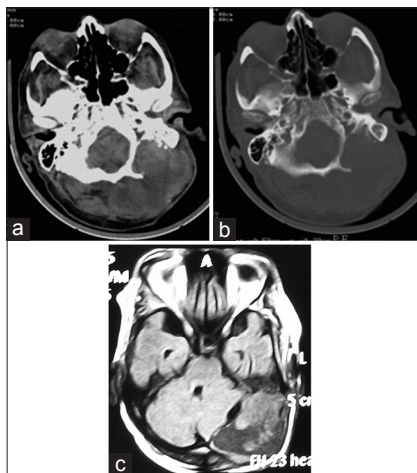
Two months after previous surgery, brain computed tomography scan revealed a large heterogenous dense mass in the left occipital part of the scalp (a), associated with destruction of the occipital bone (b), brain magnetic resonance imaging showed a heterogenous lesion including cystic and solid components in the left side of posterior fossa (c)
